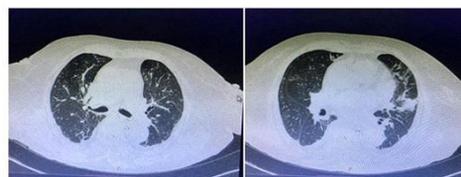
HRCT (Lung window) showing deposition of high density (HU= 3000) confirming the diagnosis of pulmonary cement embolism.
